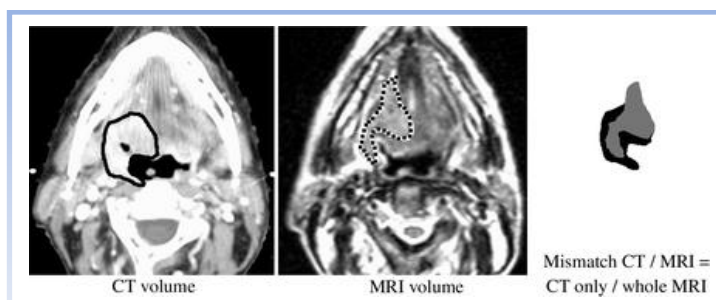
The mismatch of CT to MRI is calculated by dividing the CT volume by the MRI volume (105). This describes what fraction of the MRI volume that would have to be added in order to cover the CT volume
